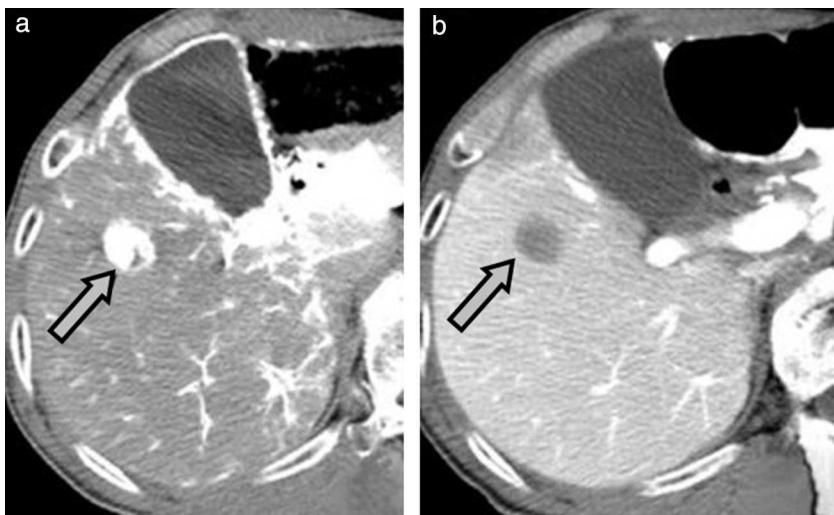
HCC during dynamic CT (arrow): arterial phase (a) and portal phase (b).
